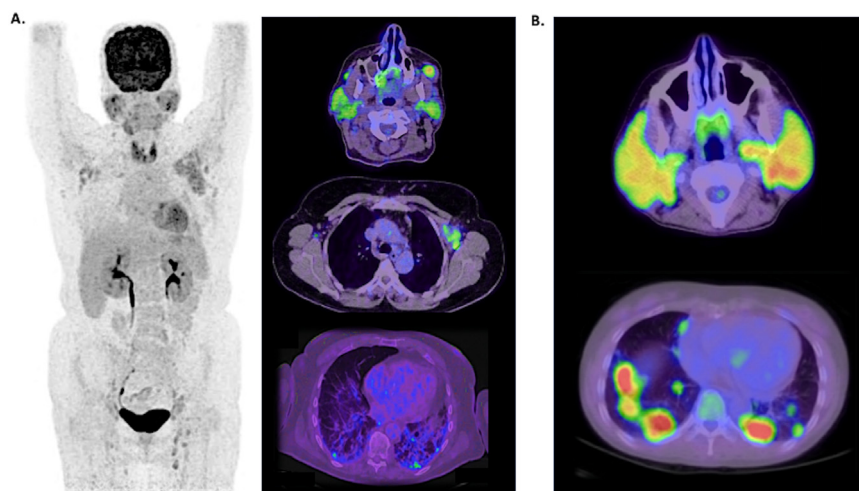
Sjögren syndrome. (A) Typical FDG-PET/CT pattern of pSS: involvement of parotid/lacrimal glands, lymph nodes at sus and sub-diaphragmatic levels, and interstitial lung disease. (B) Red flags highly suggestive of lymphoma transformation: increased size of parotid glands with high FDG uptake; hypermetabolic nodular opacities in the lungs.
